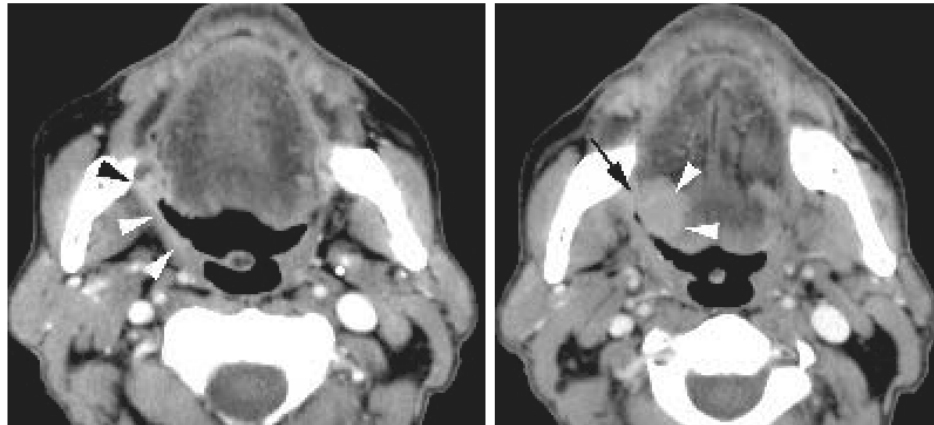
CT Scan of neck showing right sided oro-pharyngeal mass (Arrow).
